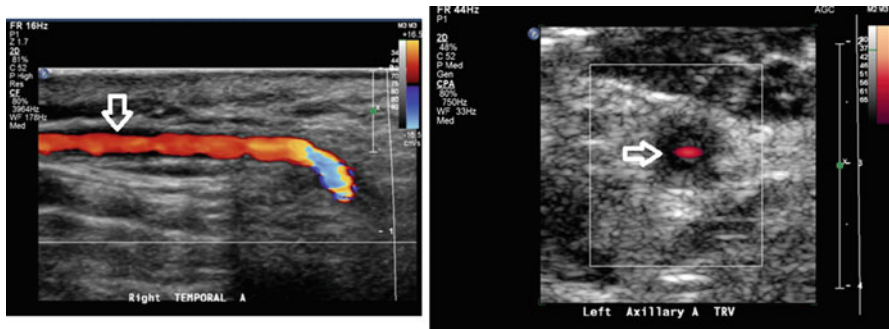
Duplex ultrasound of an elderly man with Giant cell arteritis showing vessel wall inflammation in the form of thickening (see *arrows*) in the right temporal artery and the left axillary artery (Halo sign). Acknowledgement: Image provided by Heather Gornik, MD (Cleveland Clinic)
